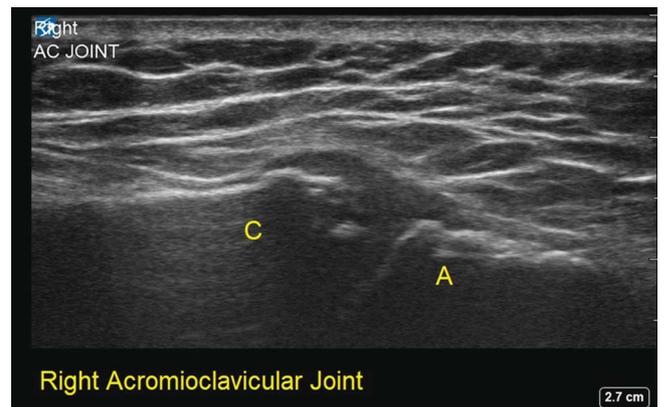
Sonographic correlate to Figure 1. There is cortical irregularity at the distal segment of the right clavicle (C). Acromion (A). Machine: Sonosite X-Porte with 6–15 MHz linear transducer.
